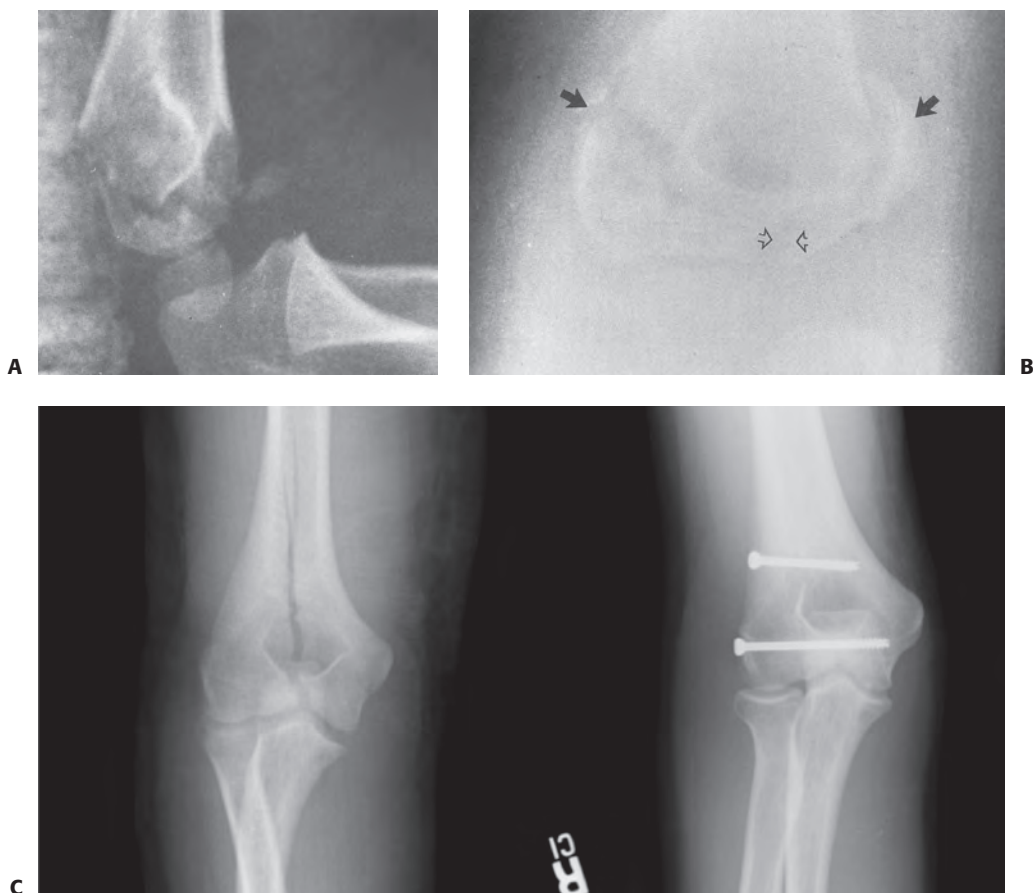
Examples of Type I T-condylar fractures. A: Lateral view of Type I undisplaced T-condylar fracture in a 6-year-old. B: AP of the t-Condylar fracture line (*open arrows*) was not appreciated until it healed. There are both medial and lateral Thurstan–Holland fragments (*solid arrows*) (Courtesy of Ruben D. Pechero, MD). C: Pre- and postoperative x-rays of minimally displaced intra-articular Type I T-condylar fracture in a 16-year-old boy treated with closed reduction and percutaneous screw fixation.
